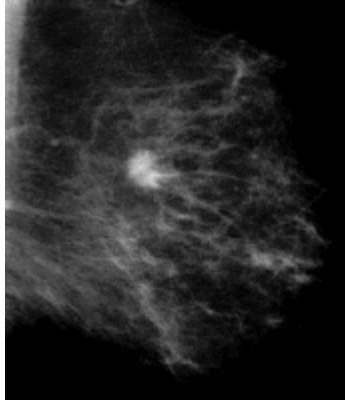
Mammogram of a tumor in fatty breast tissue. The diseased tissue attenuates photons more effectively, so the tumor shows up light against a darker background of fatty tissue. (From *Mammography: Introduction*. (2003). Retrieved December 16, 2005, from Monash University Centre for X-ray Physics and Imaging Web site: <http://cxpi.spme.monash.edu.au/index.htm>)
